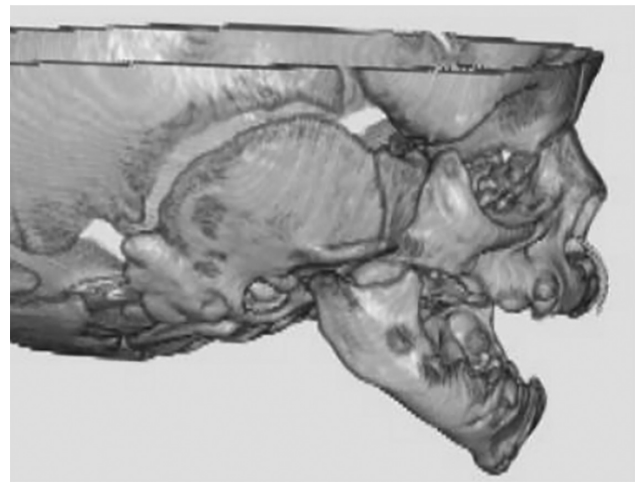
Computed tomography images showing no bony fusion.
